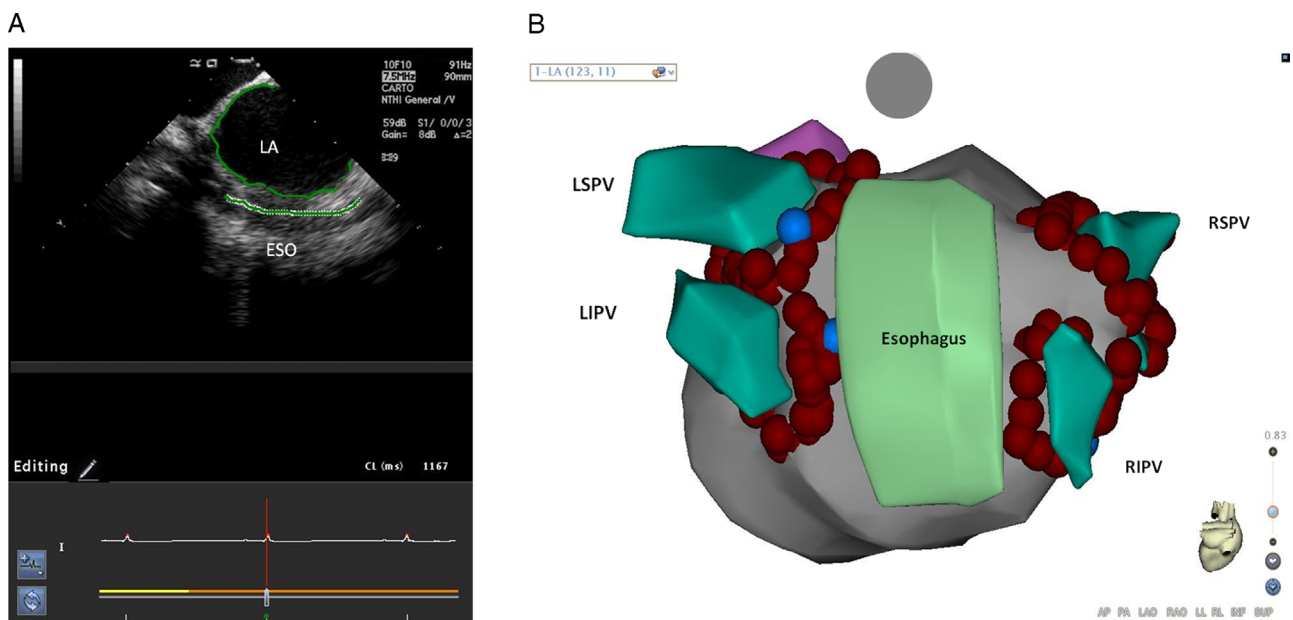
Figure Relationship of the lower esophagus, posterior left atrium, and pulmonary veins in our patient. A: Intracardiac echocardiogram image of the left atrium (LA) and the esophagus (ESO) as it courses close to the posterior atrial wall in our patient. B: Posterior view of the 3-dimensional map of the left atrium and the pulmonary veins, and the anatomic relationship between the esophagus and the ablation sites around the ostia of the pulmonary veins. Note the proximity of the esophagus to the ostia of the left upper and lower pulmonary veins. RSPV = right superior pulmonary vein; RIPV = right inferior pulmonary vein; LSPV = left superior pulmonary vein; LIPV = left inferior pulmonary vein.
